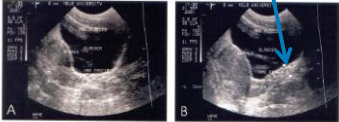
Ultrasonically marked isoperineally. Higher surface view of pelvic floor relaxed (A) and fully contracted (B), with perineal displacement.
